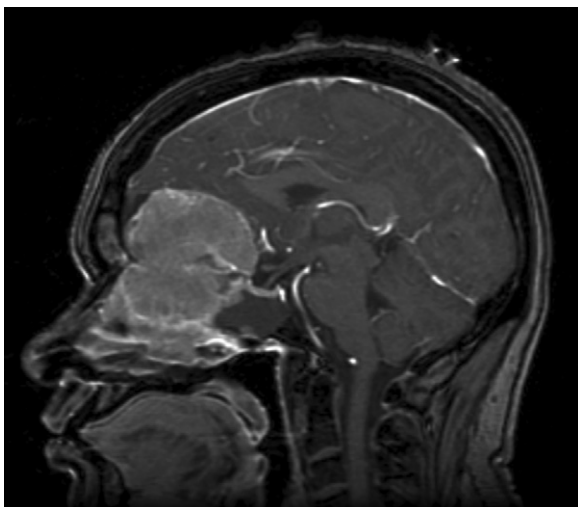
Sagittal, T1-weighted MRI with contrast of Patient 9 demonstrating the typical radiographic appearance of Kadish stage C esthesioneuroblastoma.
